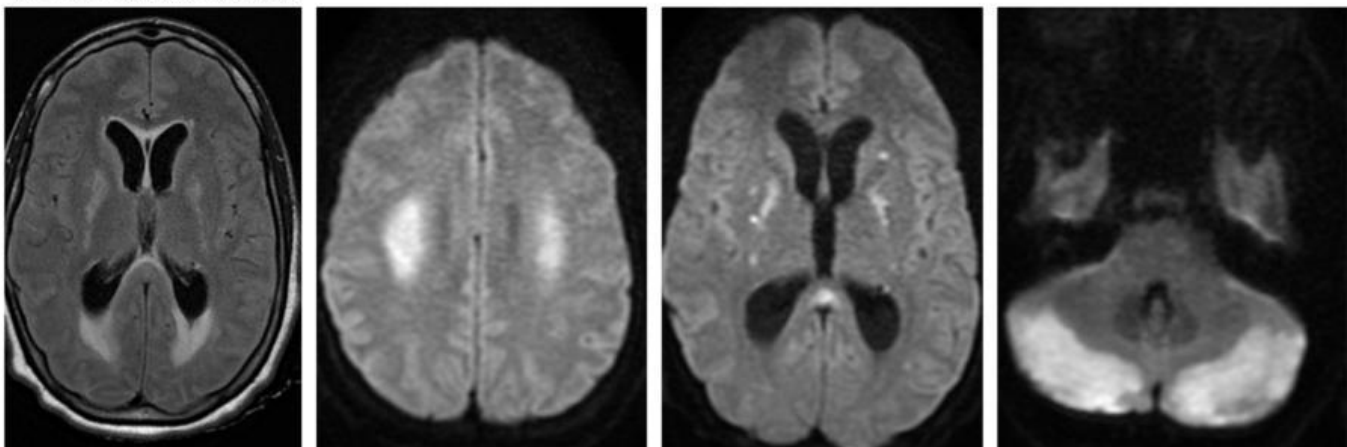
T2W FLAIR sequence (first image) demonstrates hyperintensity in the internal capsule with ventriculomegaly and juxtaventricular edema suggestive of transependymal flow of CSF. Diffusion restriction seen in the bilateral centrum semiovale, internal capsule and cerebellar hemispheres on DWI (subsequent images).
